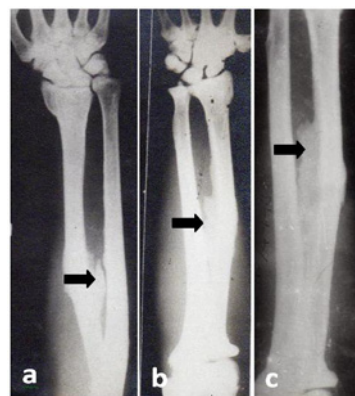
Radiographs of radius-ulna bones of forearms of subjects having mild (a), moderate (b), and severe (c) skeletal fluorosis showing progressive osteoporosis, roughening and thickening of periosteal surface, periosteal bone formation along the insertion of tendons, and ligaments. Calcification of interosseous membrane (arrow) between radius and ulna bones indicating skeletal fluorosis.
